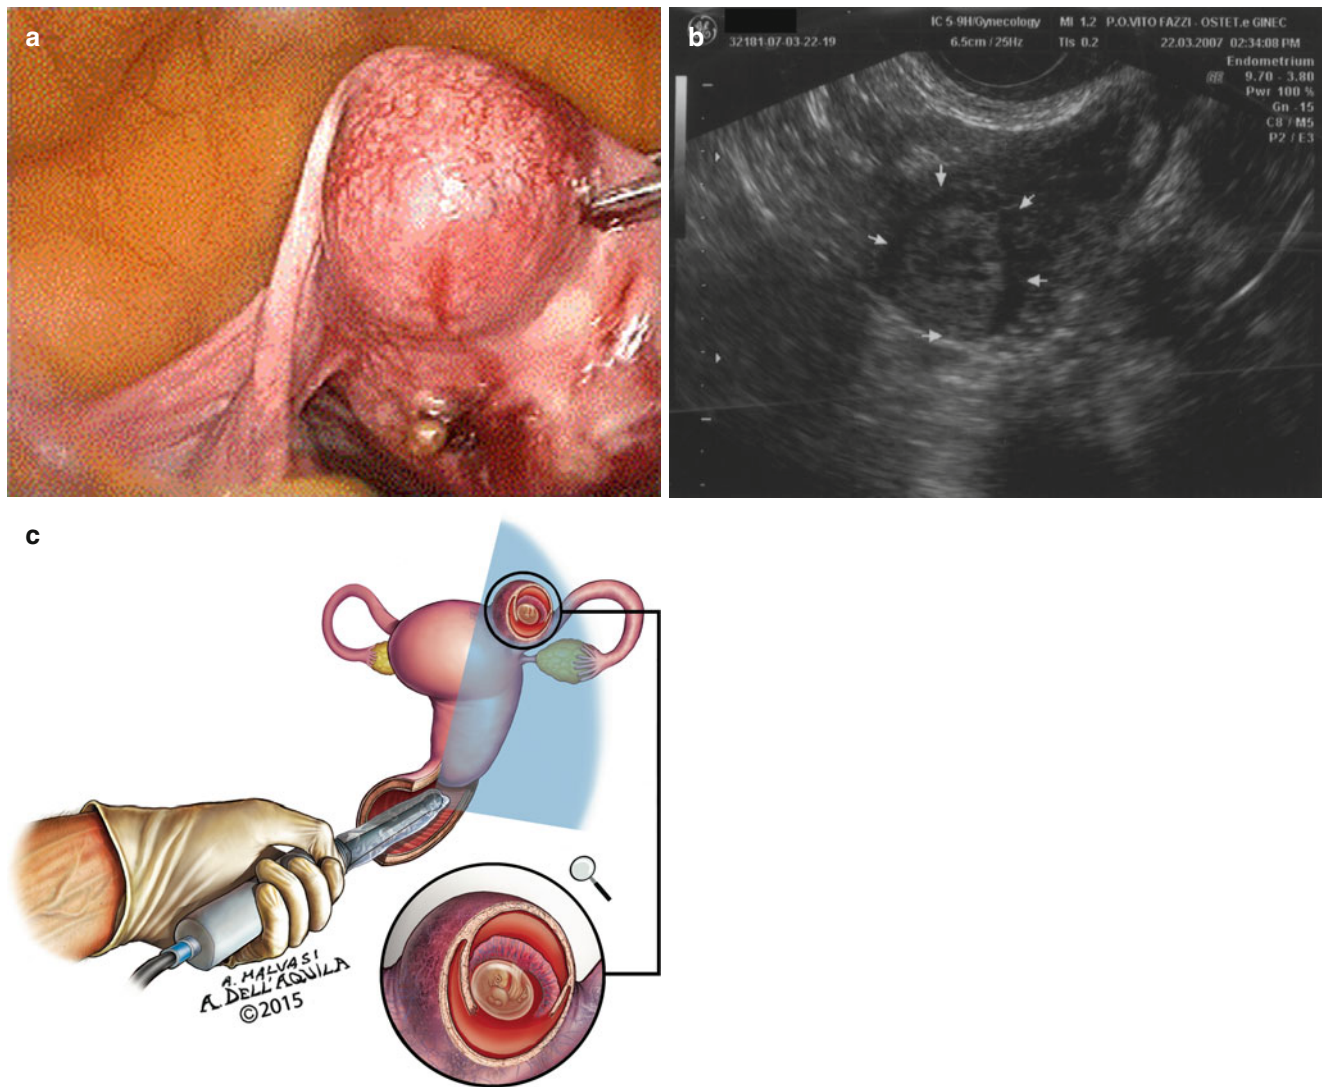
(a) Laparoscopic image of interstitial pregnancy at 6 weeks. (b) Ultrasonographic transvaginal uterine section of an interstitial pregnancy, with a chorionic sac greater than 1 cm separate from the lateral
